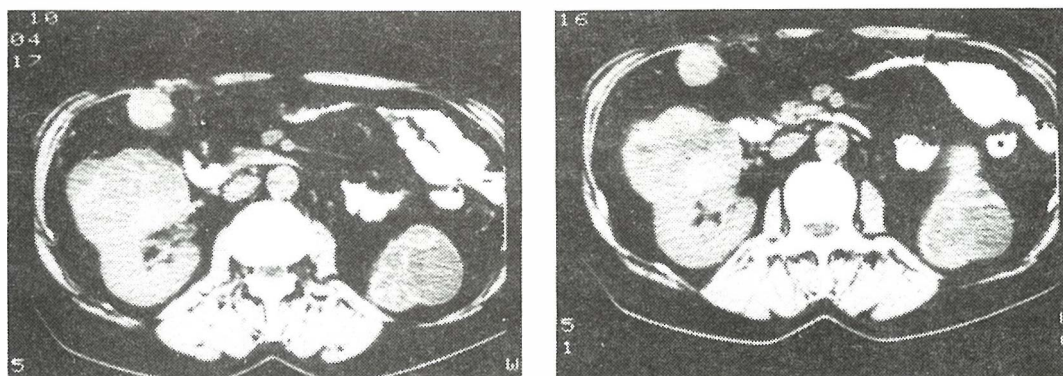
CT slices showing bilateral kidney tumors together with a metastatic lesion in the ventral part of the abdomen.
